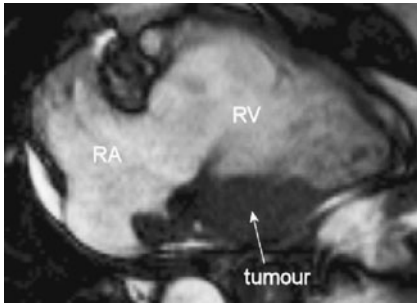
Cardiac MRI of the right heart demonstrating a mass at the junction of the right ventricle (RV) and right atrium (RA). Subsequent biopsy confirmed myocardial infiltration with lymphoma.
